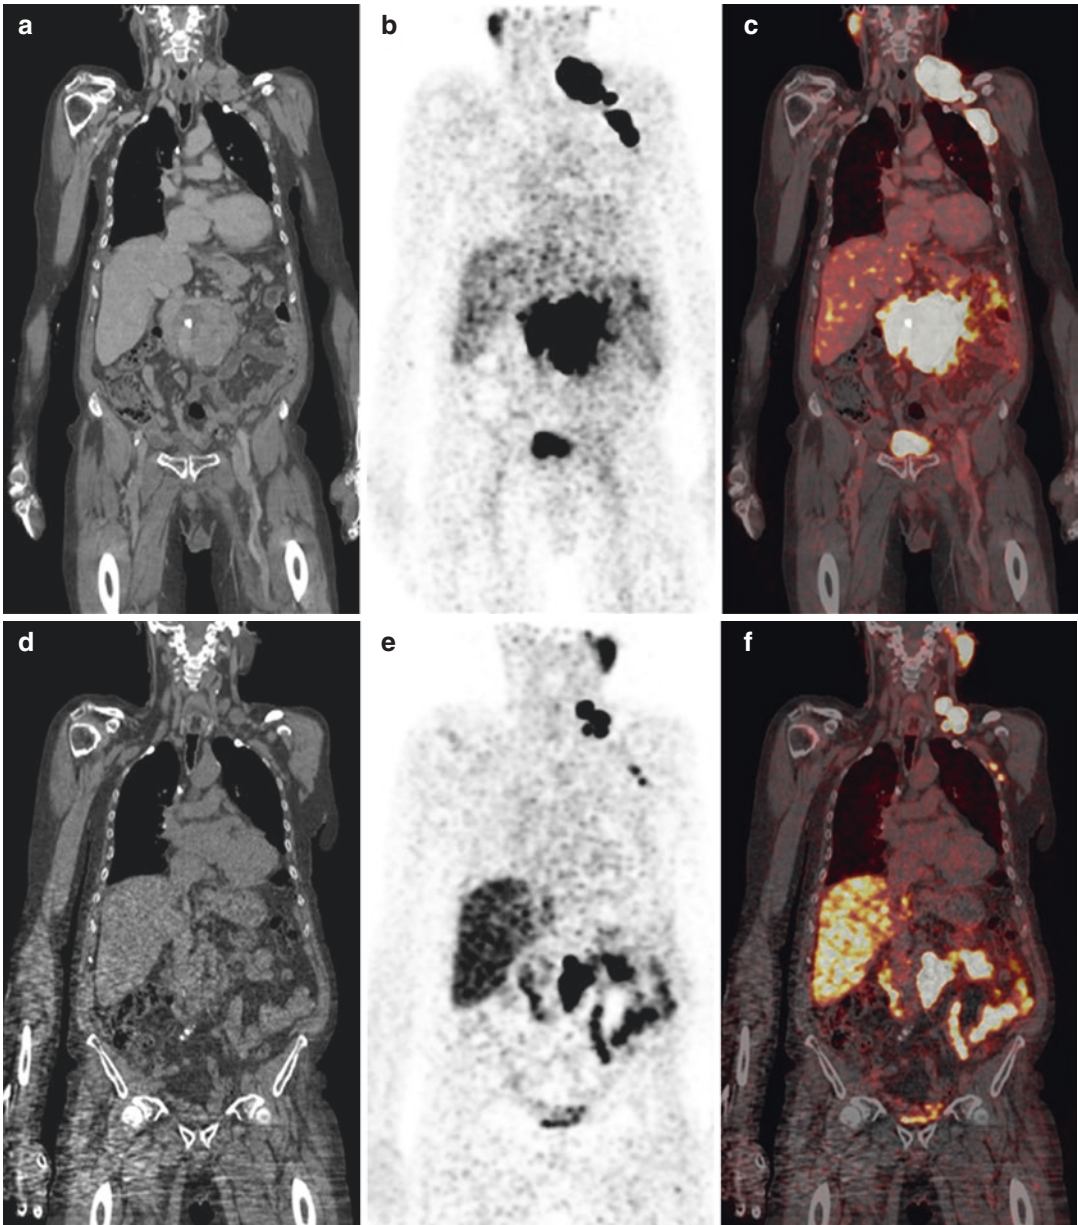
Image example of a 77-year-old patient with metastasized castration-refractory prostate cancer (initially cT3a cN1 cM0 G2b, Gleason score of 7). Patient received hormone ablation therapy, local radiation treatment and numerous systemic therapies (Zytiga®, Taxotere® and Xtandi®). Due to progressive disease, patient was referred for three cycles of ^{177}Lu PSMA therapy.
